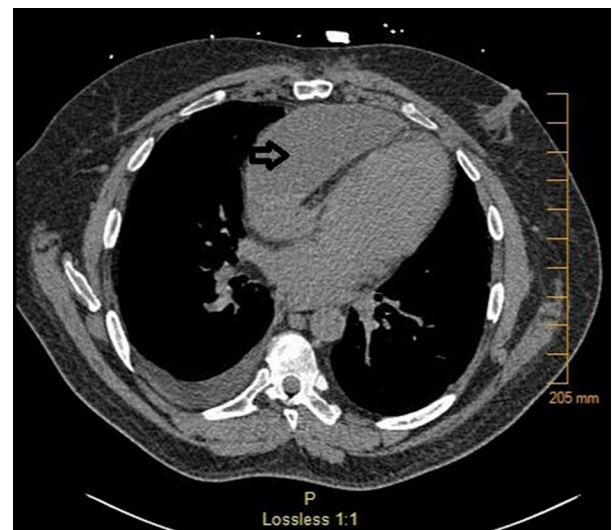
Computed tomography of the chest showing anterior mediastinal mass completely obstructing the right ventricular cavity.
